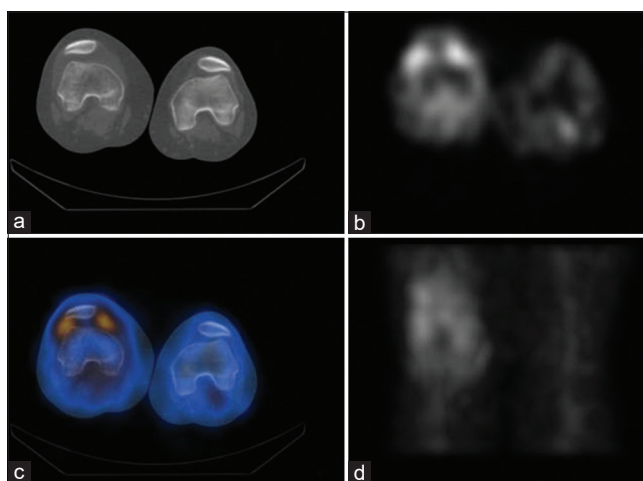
Static imaging of the knee joint performed immediately after yttrium-90 radiosynovectomy for the demonstration of radiopharmaceutical distribution in the right knee joint. Sagittal computed tomography (a), sagittal single-photon emission computed tomography (b), fused single-photon emission computed tomography/computed tomography (c), and coronal single-photon emission computed tomography (d) of the knee. Imaging excluded potential extra-articular leakage of yttrium-90. Due to the lack of gamma emission from the radiotracer yttrium-90, imaging was performed with coadministration of 5 mCi of ^{99m}Tc
